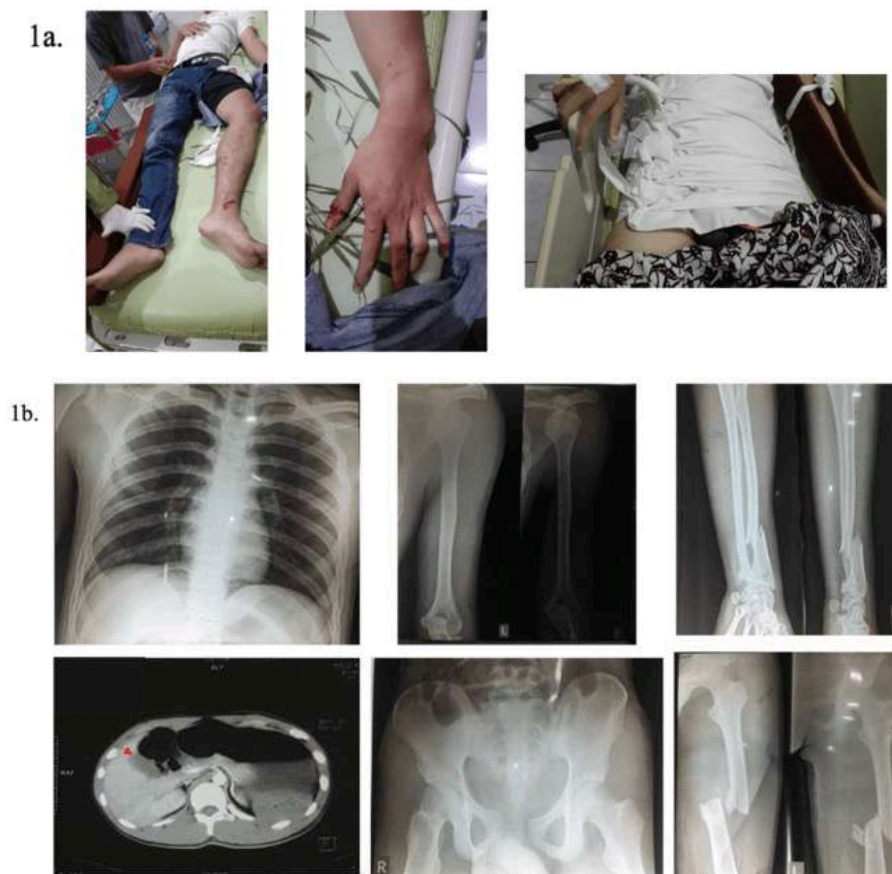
1a) Clinical Photos of the patient upon arriving at the emergency department. 2b) Plain X-ray films showing dislocation of left shoulder, multiple fractures on left wrist, pelvic, and left thigh. Abdominal CT-Scan showed minimal hemoperitoneum on the red arrow.
